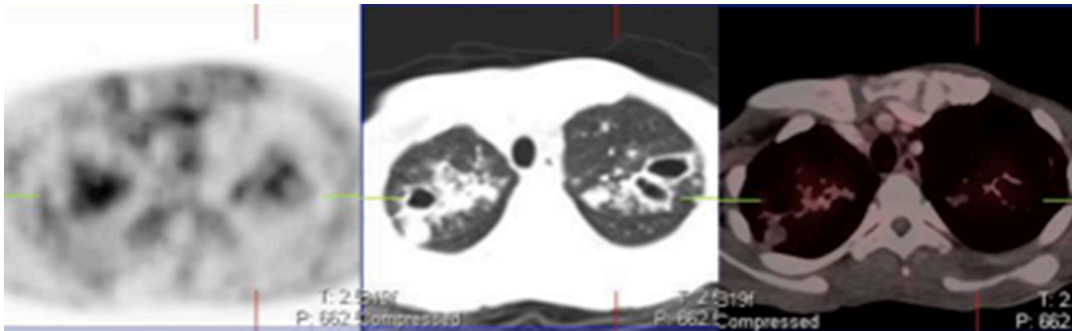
A 44 yr old male smoker with RVD who presented with bilateral apical lung changes. Transverse PET, CT and fused PET/CT images demonstrate increased tracer uptake in both apical lobes. Sputum cultures confirmed Mycobacterium Tuberculosis.
